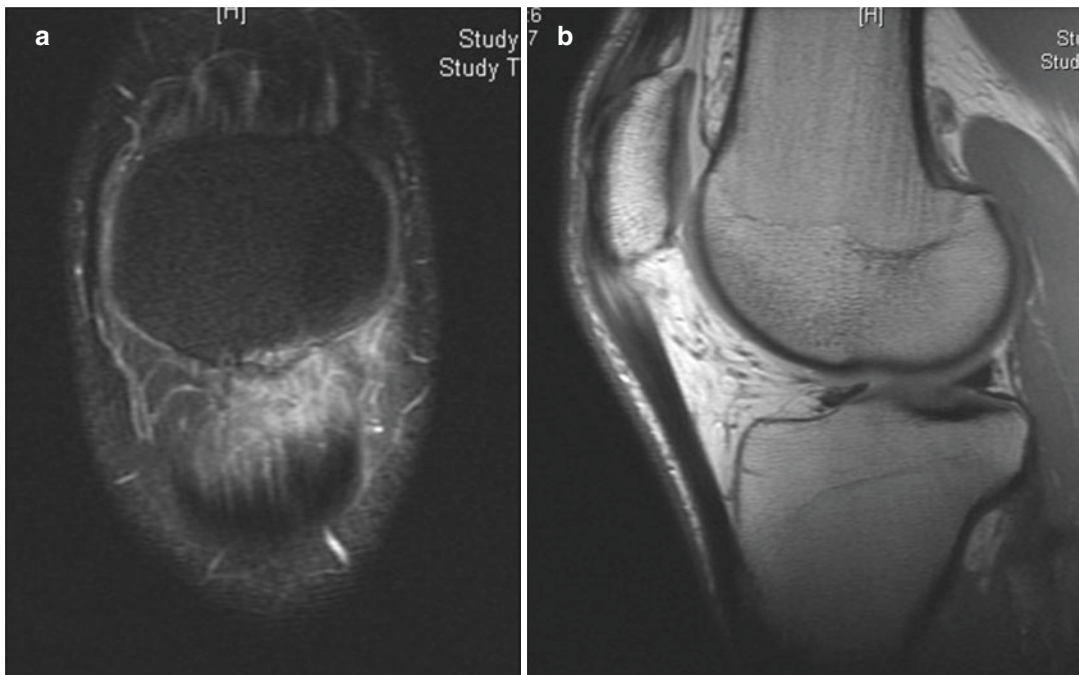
MRI of a male professional tennis player with patellar tendinitis— (a) demonstrating a coronal view with T2 weighting and (b) showing a sagittal view
